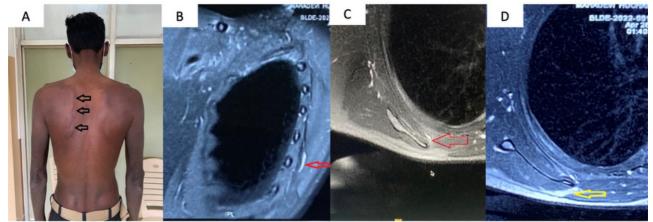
Clinical & MRI images depicting Snapping Scapular syndrome. A: Clinical image showing multiple palpable swellings along medial border of scapula(arrows) B, C & D:MRI showing infraserratus (red arrows) and trapezoid bursitis (yellow arrow)
